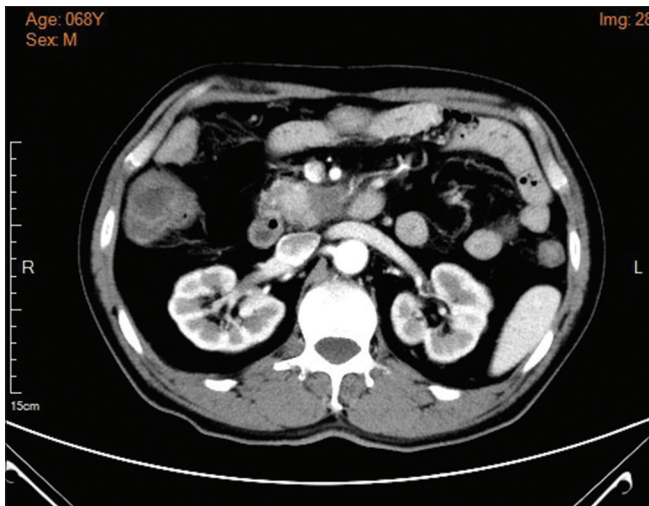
CT scan showed a suspected solid lesion in the HOP
